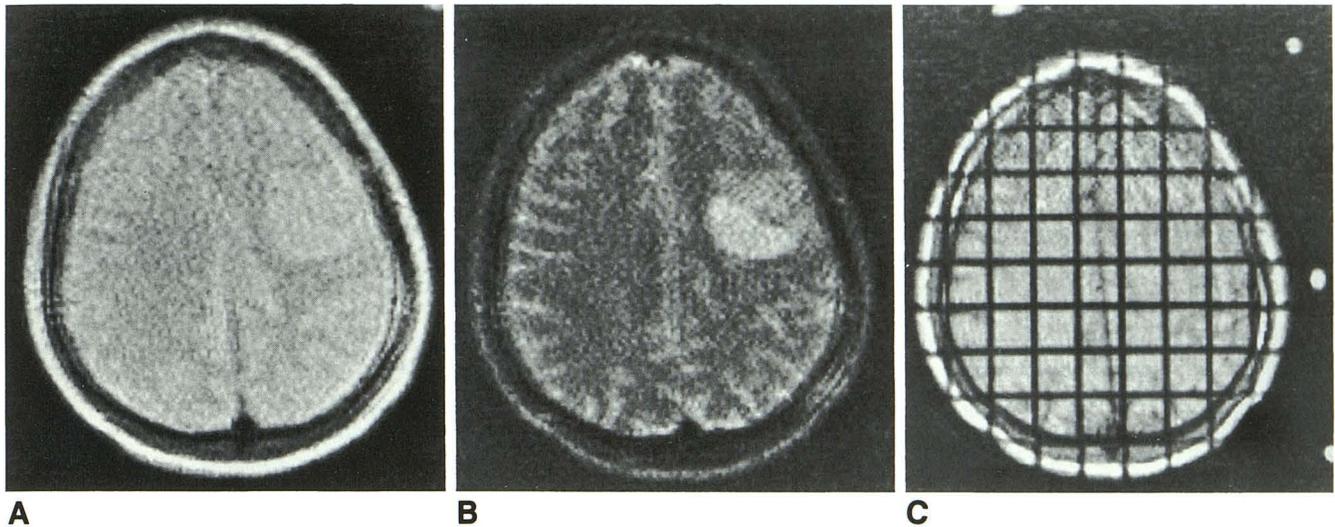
First (A) and second (B) echoes of a T2-weighted sequence (2500/22–90, (256 × 256 matrix, 350-mm field of view, 5-mm thickness, 1-mm intersection gap) obtained on a patient with a low-grade astrocytoma who underwent a stereotactic biopsy with MR guidance.
